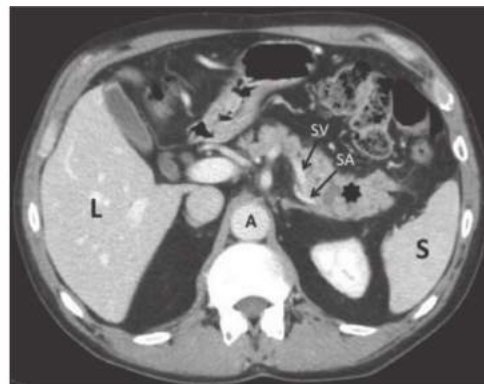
• Pancreatic protocol helical CT scan of with dual phase intravenous contrast of the abdomen and pelvis demonstrating a solid 3.6×2.9 -cm complex cystic lesion (*star*) in the tail of the pancreas concerning for malignant transformation of IPMN amenable for a DPSP. A, aorta; L, liver; S, spleen; SA, splenic artery; SV, splenic vein.
